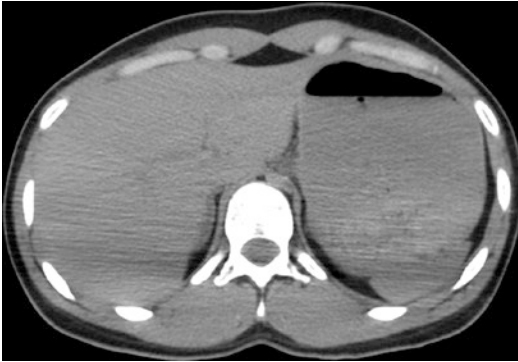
Axial abdominal CT scan shows the multilayered content inside the stomach showing different density: higher density in the fundus and air on the top
